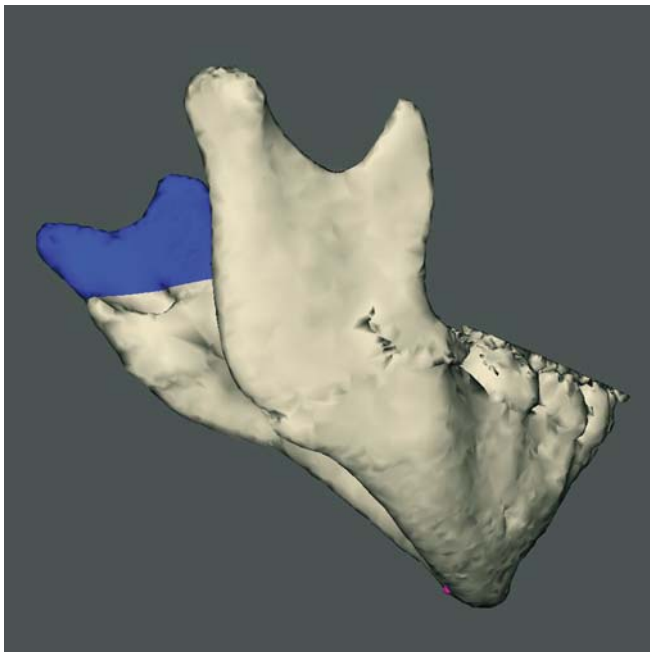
Close-up view of the isolated mandible shows that the virtual horizontal osteotomy of the left vertical ramus is planned just above the entrance (lingula) of the inferior alveolar nerve in the mandible (3-D CT hard tissue surface representation, patient H.T.)
